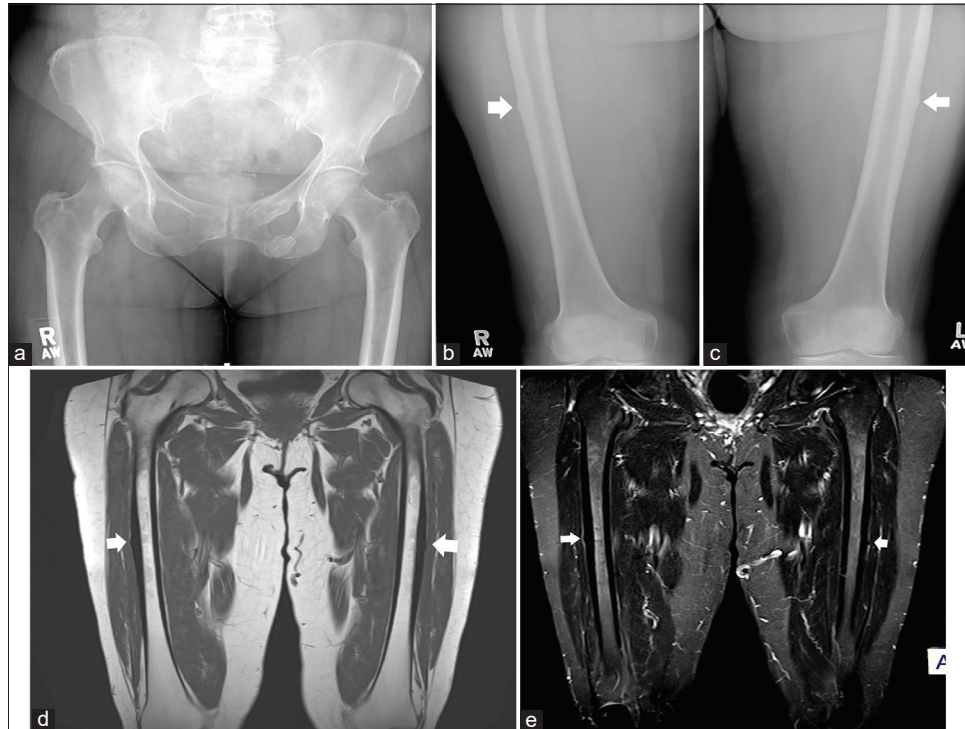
(a) A 77-year-old female presented with persistent bilateral hip pain. The pelvic radiograph demonstrated insufficiency fractures of the pubic rami. (b) Radiograph of the right femur demonstrated lateral cortical thickening along the mid-shaft of right femur (solid white arrow). (c) Radiograph of the left femur demonstrated lateral cortical thickening along the mid-shaft of left femur (solid white arrow). (d) MR coronal T1W sequence in the MR study demonstrated lateral cortical thickening (solid white arrows) along the mid-shaft of bilateral femora. (e) MR coronal STIR sequence in the MR study demonstrated no evidence of bone marrow edema. However, the bilateral cortical beaking is again noted (solid white arrow). MR: Magnetic resonance, STIR: Short-tau inversion signal.
